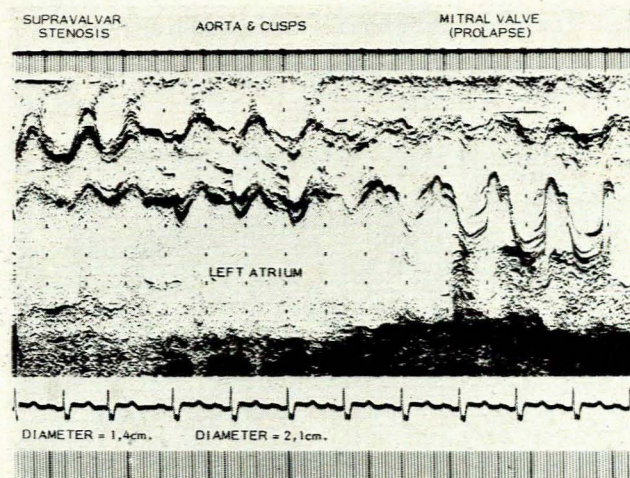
M-mode echocardiogram demonstrating supra-valvular stenosis with 7 mm reduction in aortic diameter. Prolapse of posterior mitral leaflet into dilated left atrium is clearly visualized.
